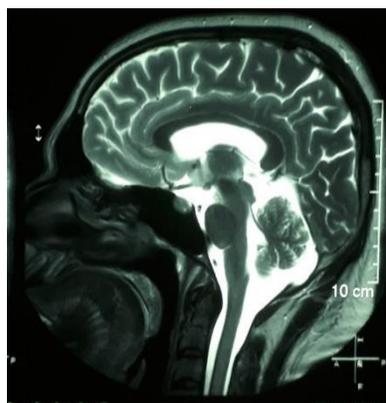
MRI T2W imaging showing hyperintense pituitary lesion of 1.5 mm x13.2 mm x 4.3 mm size
